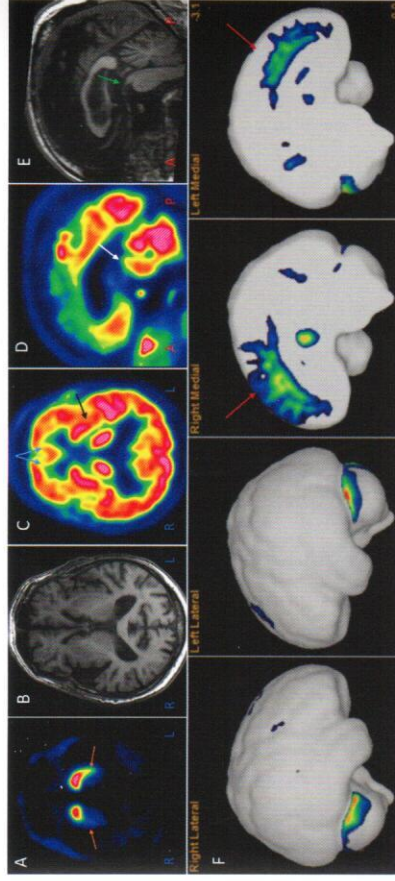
Example of $[^{11}\text{C}]\text{PE2I}$ PET/MR images in a patient with progressive supranuclear palsy with predominantly left-sided clinical symptoms, axial rigidity and impaired eye gaze. (A) $[^{11}\text{C}]\text{PE2I}$ images of DAT availability showing reduced uptake in striatum (orange arrows), more pronounced on the right side. (B) MR image (T1-weighted sequence) showing no abnormalities in the striatum. (C) $[^{11}\text{C}]\text{PE2I}$ image of rCBF showing decreased perfusion bilaterally in medial frontal cortex (blue arrows) and in left putamen (black arrow). (D) $[^{11}\text{C}]\text{PE2I}$ image of rCBF showing decreased perfusion in midbrain (white arrow). (E) MR image (T1-weighted sequence) showing midbrain atrophy (green arrow). (F) 3D surface projection map showing perfusion z-scores compared to a healthy control database, indicating decreased perfusion bilaterally in medial frontal cortex and anterior cingulate gyrus (red arrows).
